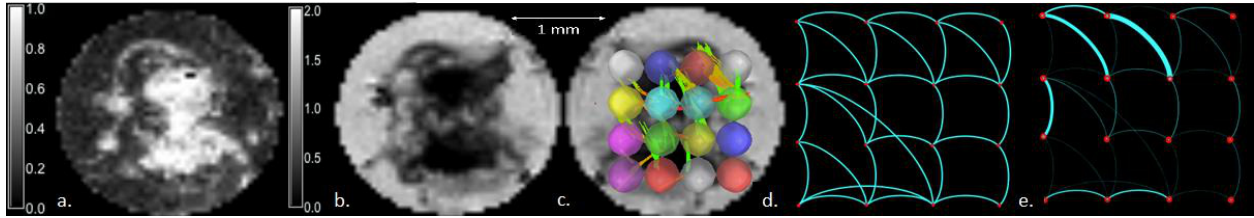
(a) FA map generated using DSI studio of an example aplysia ganglion calculated from 18 directionally unique DWI and 4 unweighted MRI. (b) Mean ADC map (c) 16 local communities were used to assess DTI-based connections between nodes. Tracts were established using thresholds of: FA=0.2, Track Counts= 10^6 & Angular Threshold= 30° . (d) Reconstruction of the binary inner-connections using Gephi (e) Weighted connecting edges in the neural ganglia
